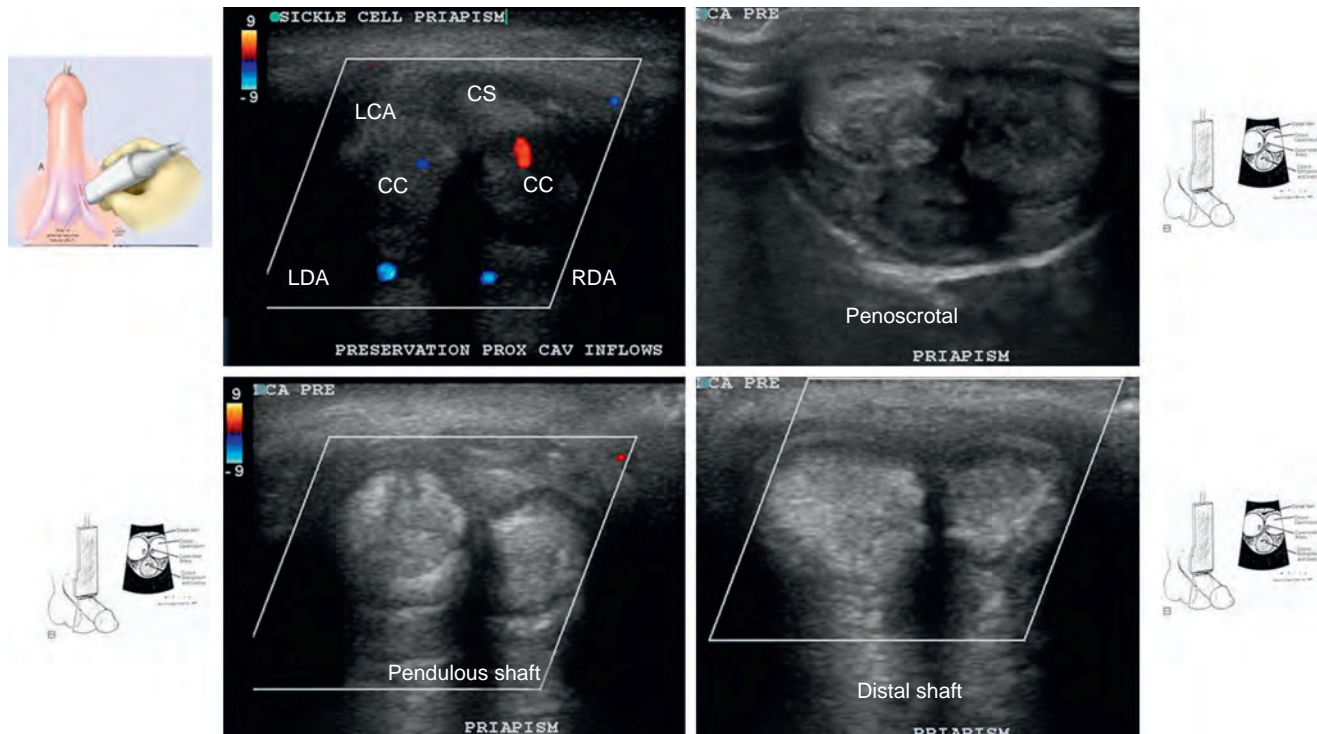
This 21-year-old Nigerian man had erectile dysfunction after recurrent episodes of sickle cell ischemic priapism. A, Transperineal imaging with color Doppler shows preservation of cavernous arterial inflow at the origin in the corpora cavernosa. B to D, Increasing echogenicity on gray-scale ultrasound of the penile shaft: penoscrotal, pendulous shaft, and distal shaft. These findings are the result of recurring ischemic priapism, which leaves the patient with distal corporal fibrosis. CC, corpora cavernosa; CS, corpus spongiosum; LCA, left cavernous artery; LDA, left dorsal artery; RDA, right dorsal artery.
